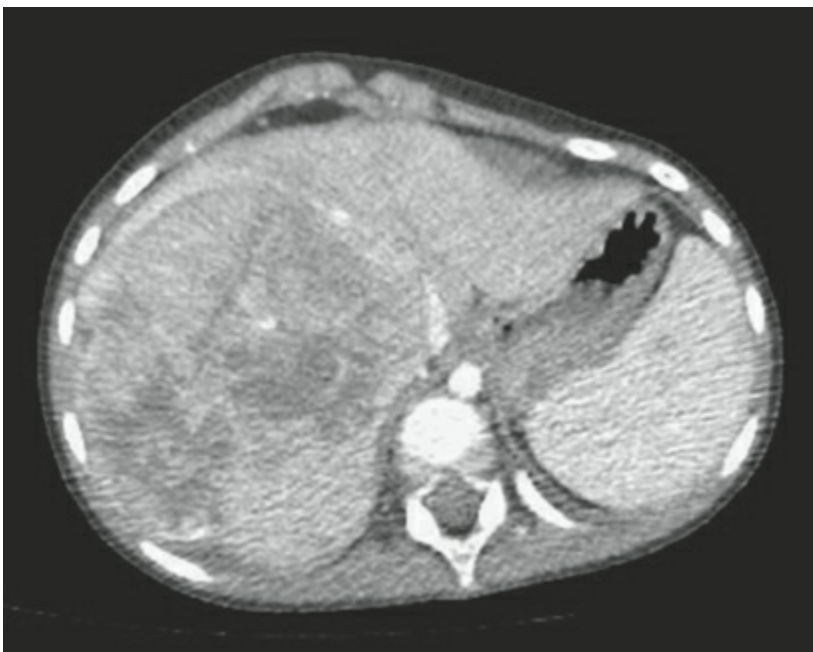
Abdominal CT scan with right hepatic lobe hepatoblastoma displacing normal hepatic vasculature and parenchyma.
